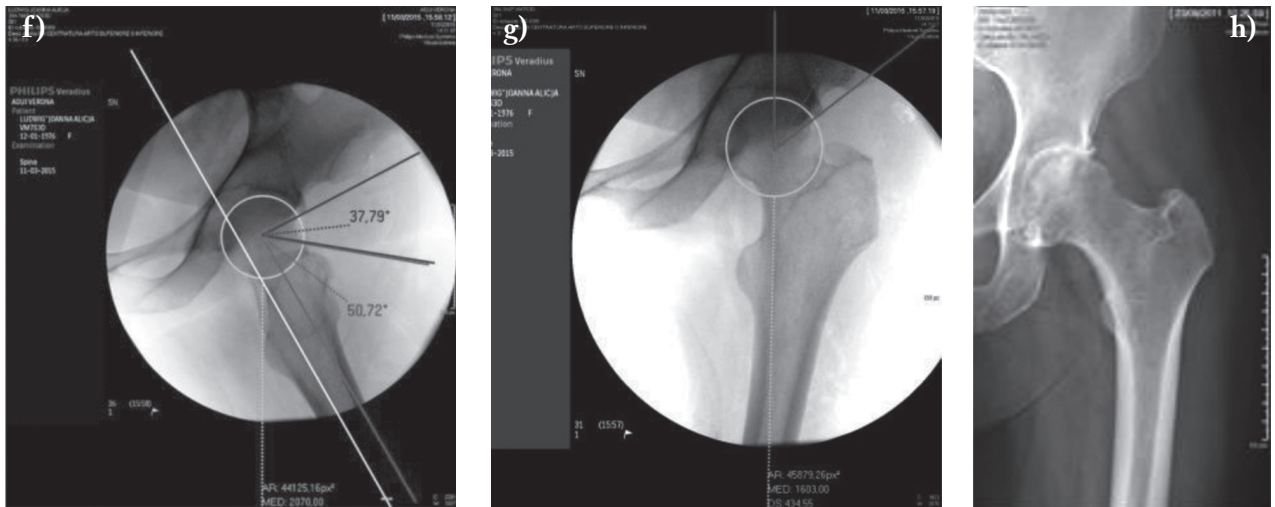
f, g, h. Post operative radiographies, surgery day (1f, 1g), after 12 months (1h)
